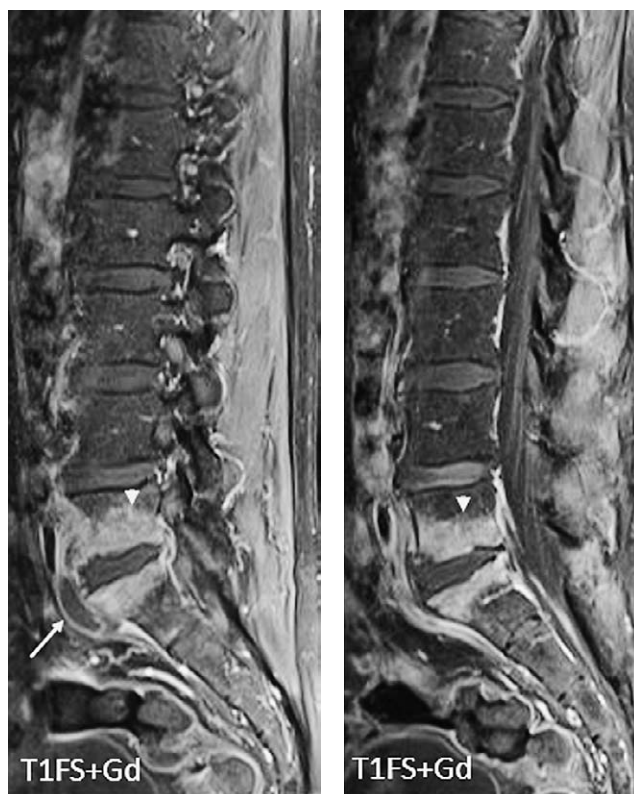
Sagittal T1 fat saturated post contrast cross-sectional MR images of the lumbosacral segment of the spine demonstrate extensive enhancement of L5 and S1 vertebral endplates, enhancement of paravertebral soft tissues and epidural abscess in keeping with spondylodiscitis of the L5/S1 segment. Arrowhead: bone oedema/osteitis – high signal in T1FSGd; long arrow: epidural abscess – low signal in T1, low signal in the centre (necrotic content) and post contrast peripheral enhancement.
